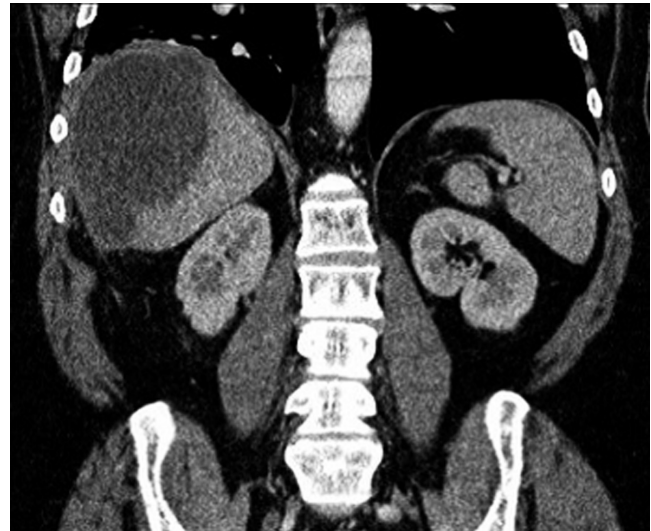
Coronal reconstruction of abdominal CT. Large right perihepatic fluid collection due to a dropped gallstone in a patient with history of pycholecysto and laparoscopic cholecystectomy four months ago.
